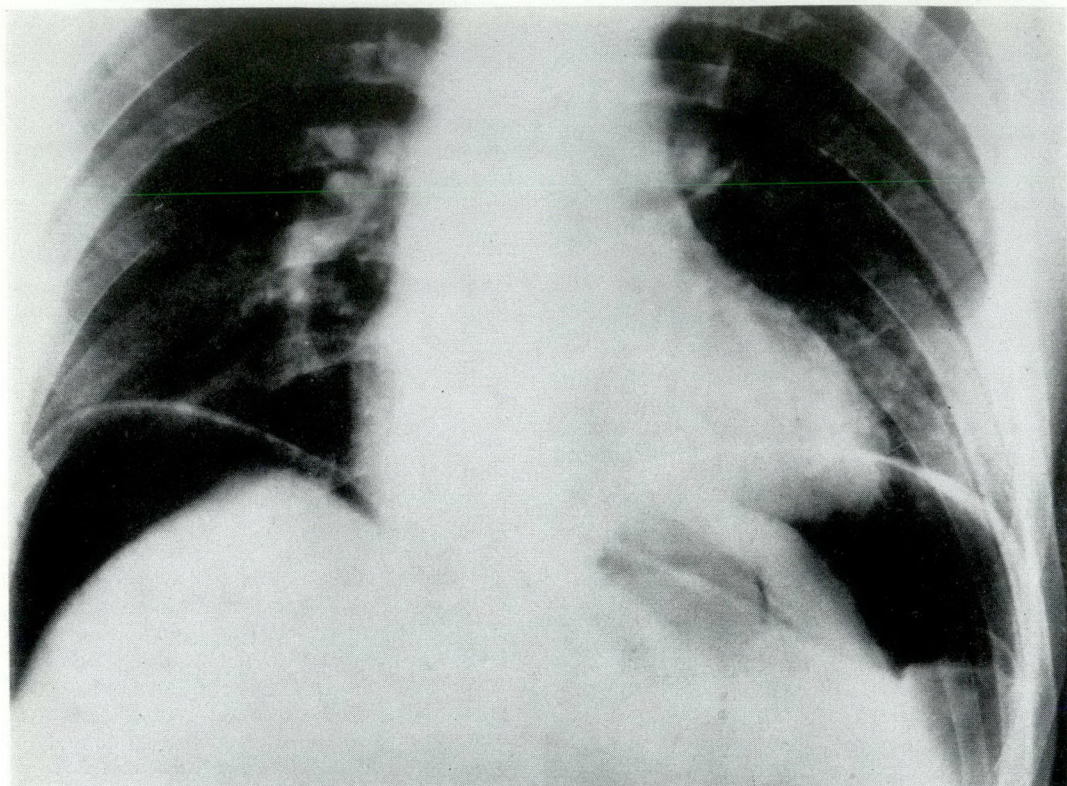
Erect plain film of abdomen showing large amount of air under both diaphragms (Case 13).
